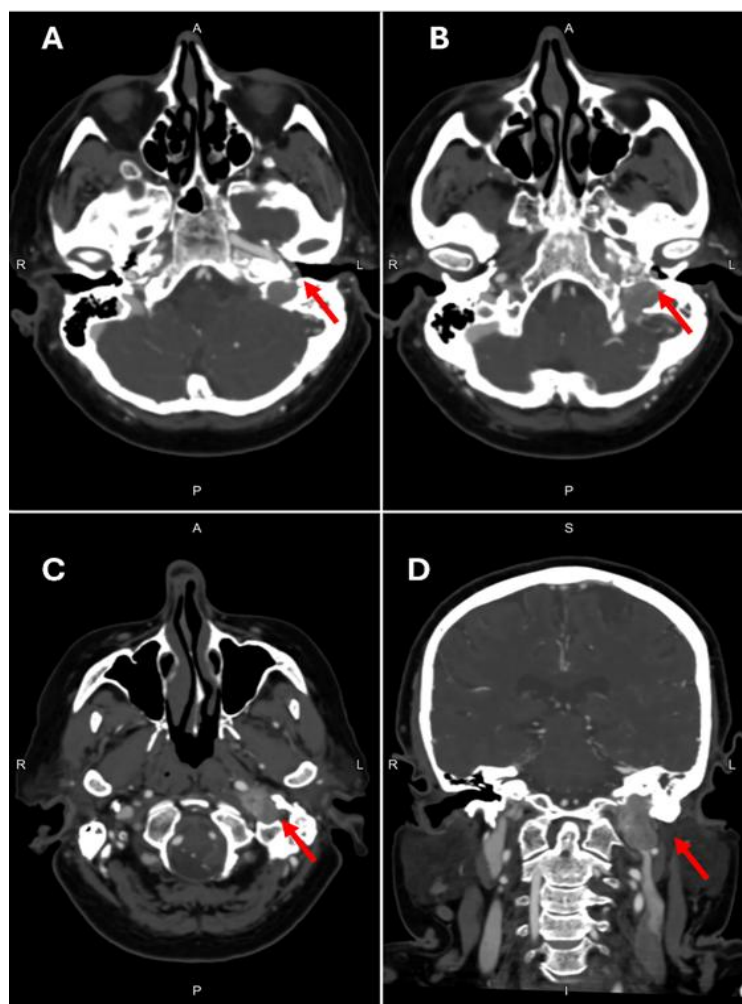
CT scan of the brain with contrast
